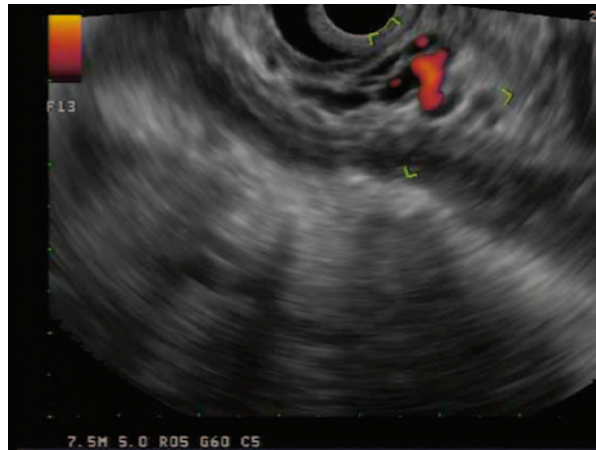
EUS evaluation of gastric wall of WOPN. Multiple collateral vessels sonographically visualized precluding transmural drainage. *EUS* endoscopic ultrasonography, *WOPN* walled-off pancreatic necrosis
